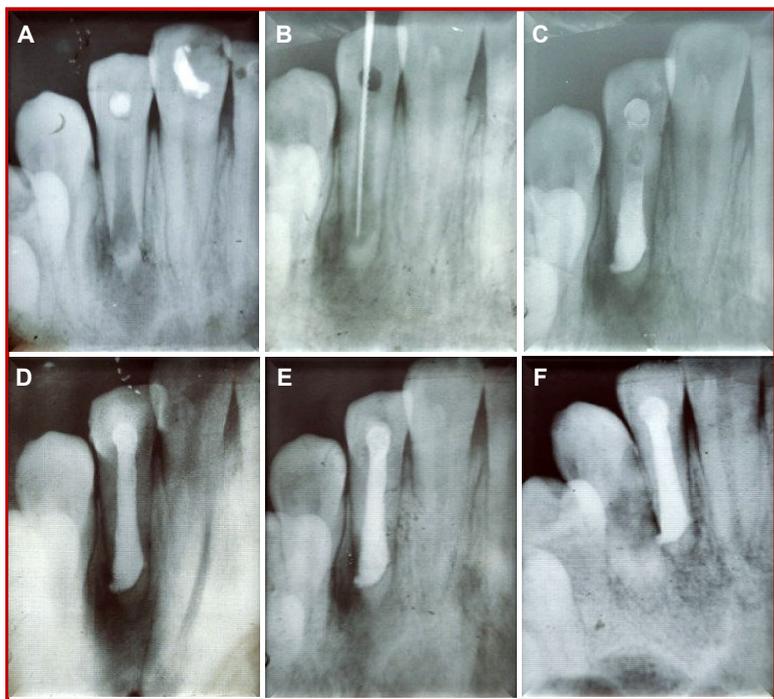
Pre-operative radiograph shows an internal resorption in the apical third portion of the root with perforation along with large periapical radiolucency. The canal is wide due to incomplete root development (A); A gutta percha is placed which reached up to the area of resorption (B); Repair of the apical part by mineral trioxide aggregate (C); The remaining canal was sealed by gutta-percha and sealer (D); One month follow-up (E); After one year (F)
